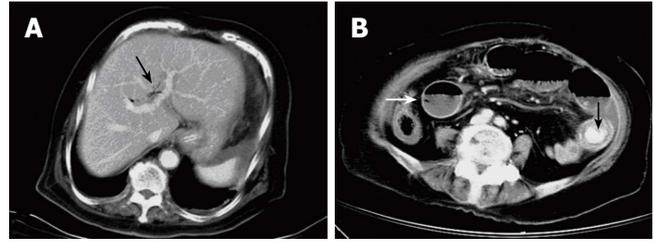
Abdominal computed tomography scan showing air in the biliary tree (arrow) (A) and an ectopic stone (arrow) impacting the jejunal lumen accompanying dilatation of proximal small bowel loops (white arrow) (B).
